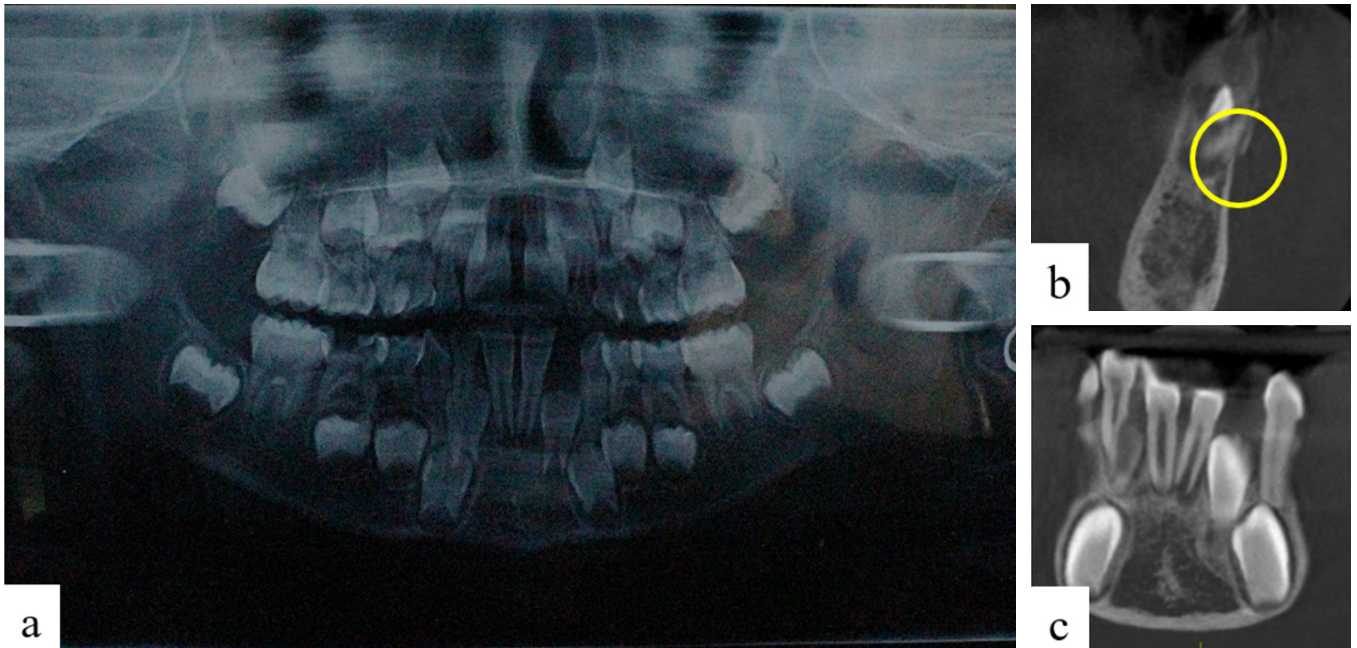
(a) Orthopantomogram inconclusive of any fracture; (b, c) Cone beam computed tomography showing buccal cortical plate fracture in the region of 31 and 32 with no tooth involvement in the line of fracture.
